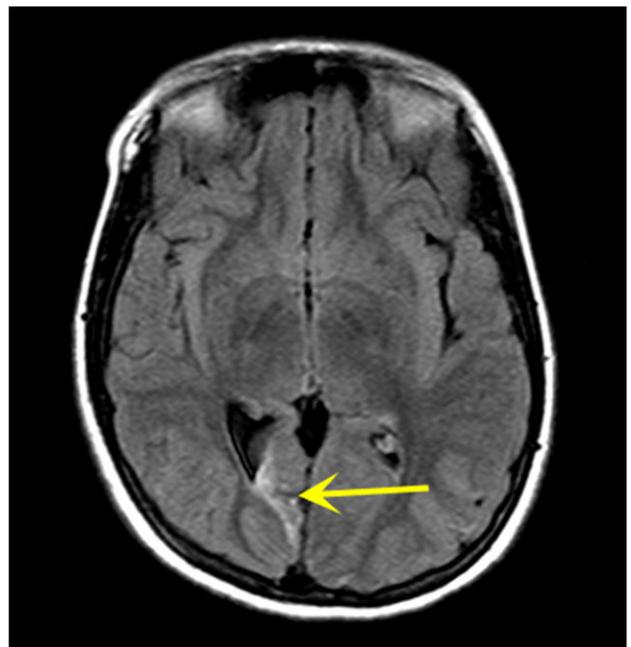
Preoperative MRI showing white matter lesion in area of CT calcifications, possible vascular degenerative (developmental venous angioma).
